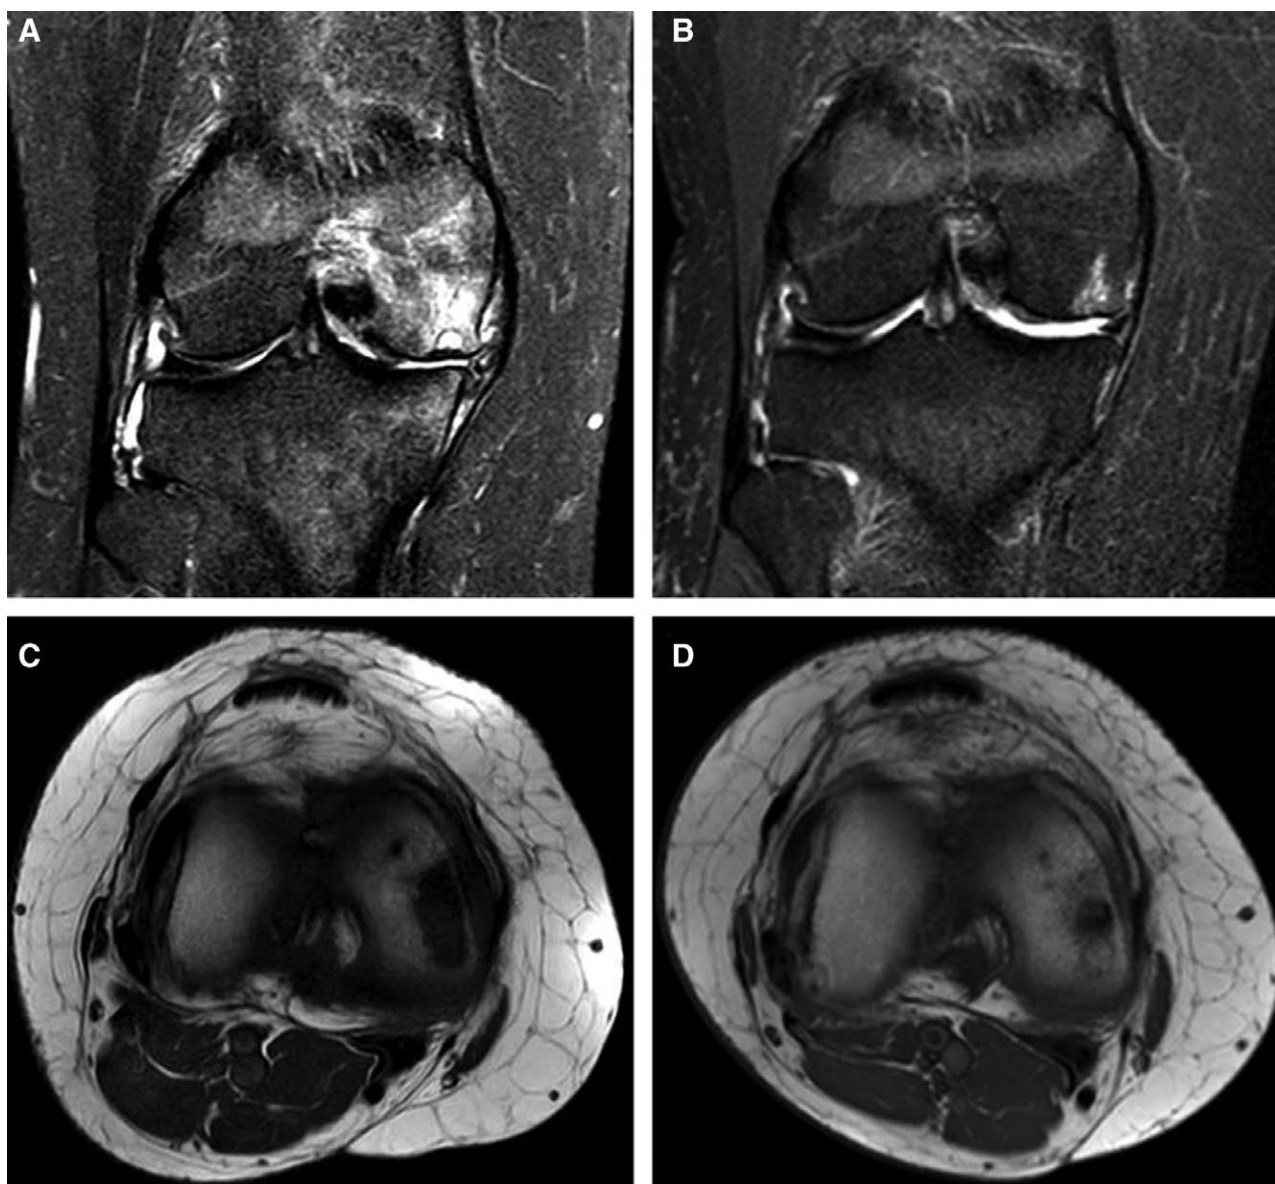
A 51-year-old woman who received right knee PFO surgery due to SONK. Coronal and axial MRI revealed a large hyperintense area on the T2-weighted image (A) and hypointense area on the T1-weighted image (C). Significant reduction of the osteonecrotic area after surgery on T1- (B) and T2-weighted images (D).
